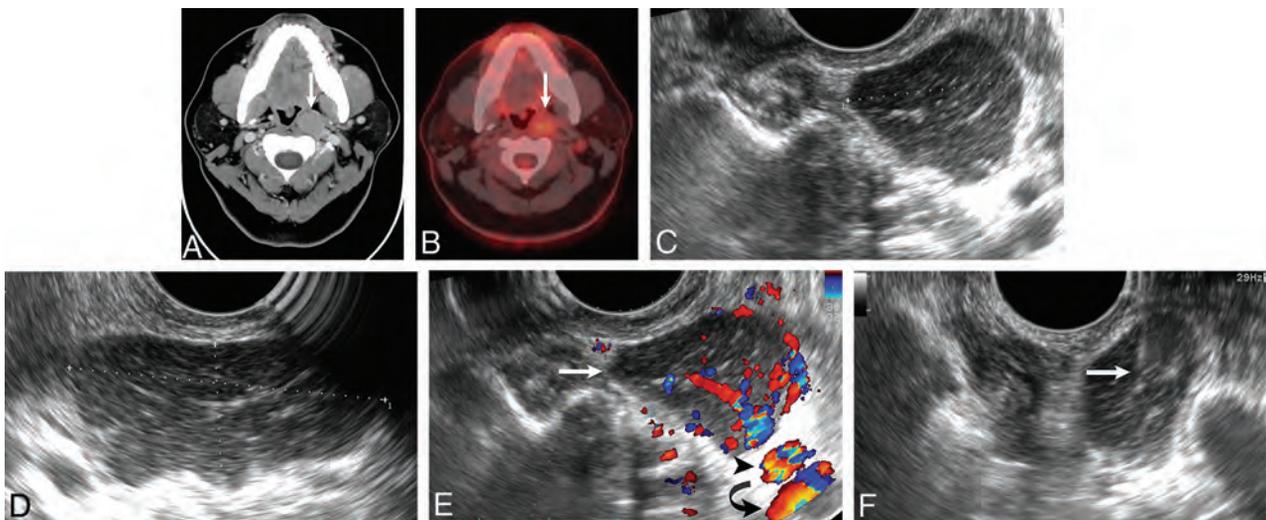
True-negative cytology. A 38-year-old woman with a history of papillary thyroid cancer and left retropharyngeal mass. *A*, Axial contrast-enhanced CT scan shows an enlarged left retropharyngeal node (*arrow*). *B*, Axial PET/CT shows that the enlarged left retropharyngeal node has mild FDG avidity (*arrow*). Transverse (*C*) and sagittal oblique (*D*) sonography reveals an enlarged hypoechoic left lateral retropharyngeal node measuring $2.5 \times 4.3 \times 1.9$ cm. *E*, Transverse color Doppler sonography shows the vascular flow of the lesion (*white arrow*) and its relationship to the internal carotid artery (*black arrowhead*) and internal jugular vein (*black curved arrow*). *F*, Transverse sonography during biopsy of the mass documents placement of needle tip (*arrow*) within the lesion before and during aspiration. Cytology revealed benign reactive hyperplasia.
